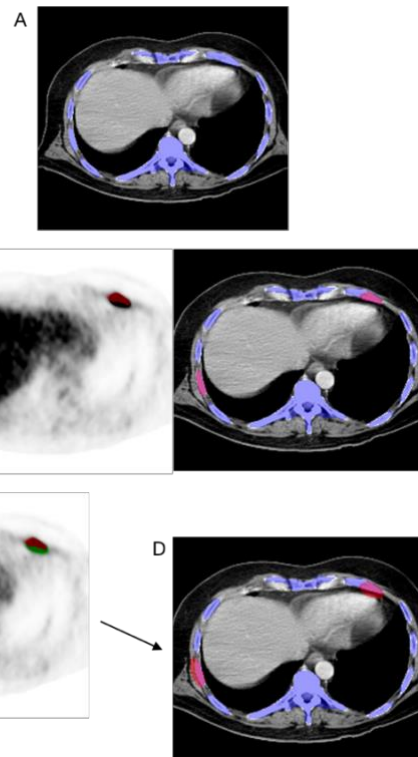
The extend bone lesion algorithm. Firstly, the bone mask is automatically computed (A) and the $\text{SUV}_{\text{thr_bone}}$ is applied (B). Then an $\text{SUV}_{\text{thr_st}}$ of 3 is computed to segment bone lesions located outside bone mask (C). Finally, the algorithm is applied and soft-tissue lesions that are in conjunction with bone lesions are automatically assigned to bone lesions (D).
